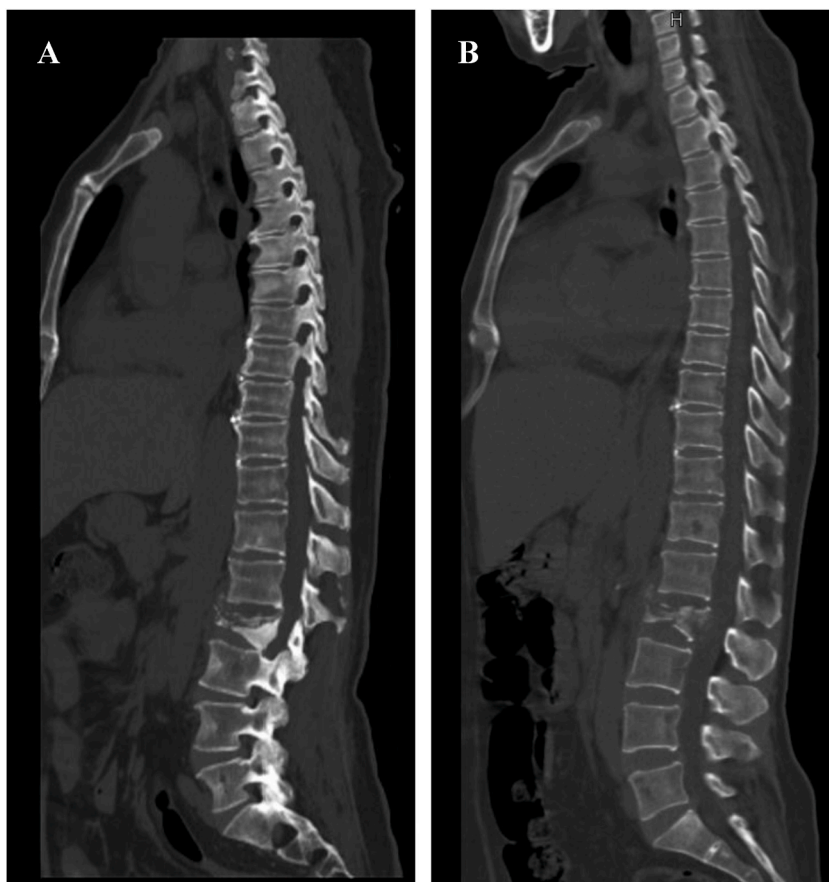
CT scans of the thoracic and lumbar spine.
